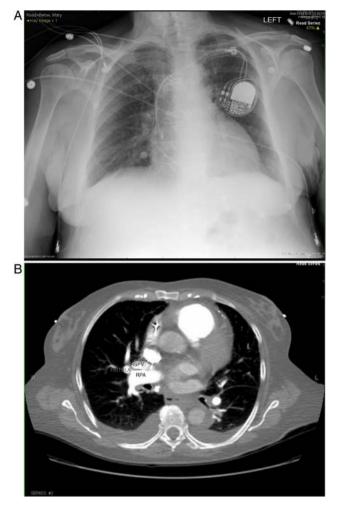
(A) Chest roentgenogram showing clear lungs. (B) Chest CT with pulmonary embolism protocol. The fistula is labelled (RSPV, right superior pulmonary vein; RPA, right pulmonary artery).
